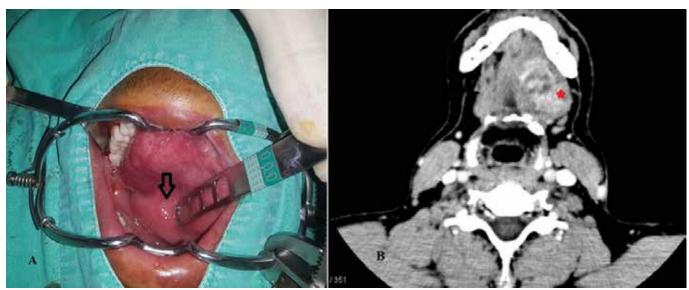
(A) Preoperative view of the lesion of the left floor of the mouth. (B) Axial contrast-enhanced CT scan demonstrated a well-circumscribed, enhancing solid mass in the left sublingual region.
